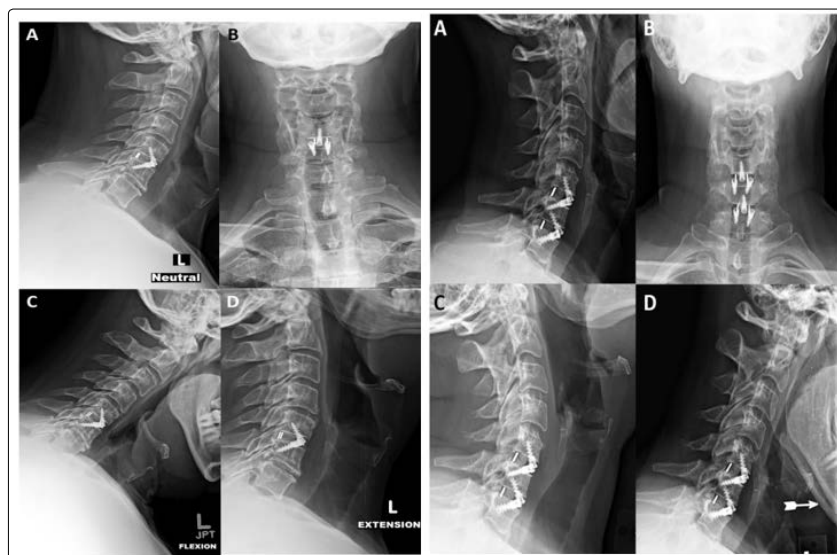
Postoperative x-rays of a single level STALIF C-Ti implant at C5-6, demonstrating upright lateral (image A), anteroposterior (image B), extension (image C), and flexion (image D) views.
